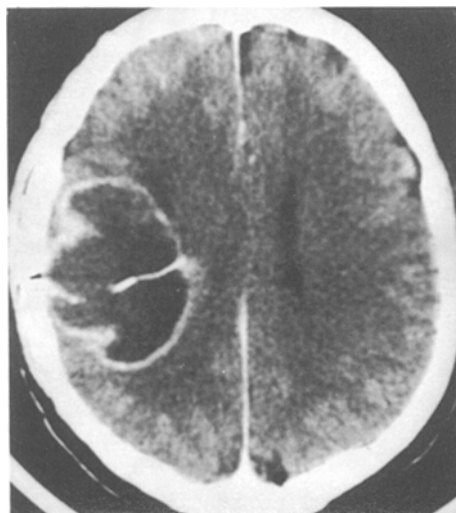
CT scan of the brain of patient 1 after 14 days' treatment with DAB. The microdialysis probe in the tumour of the right parietal lobe is surrounded by a huge necrosis not observed before treatment. Survival time after DAB treatment: 16 months
